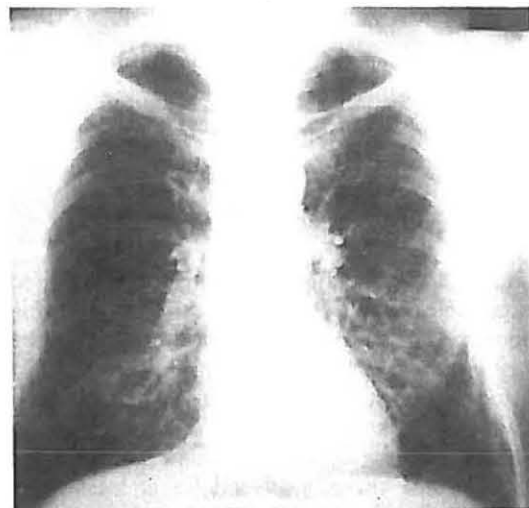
Category 1/1 film demonstrating small rounded opacities predominantly in upper lung fields. (Courtesy of ILO U/C International Classification of Radiographs of Pneumoconiosis.)
